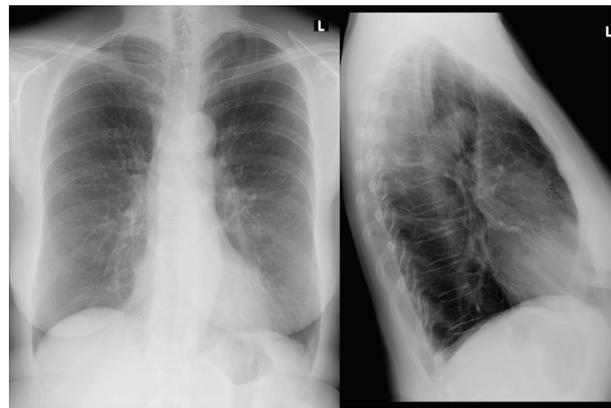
Chest x-ray taken after full recovery.
